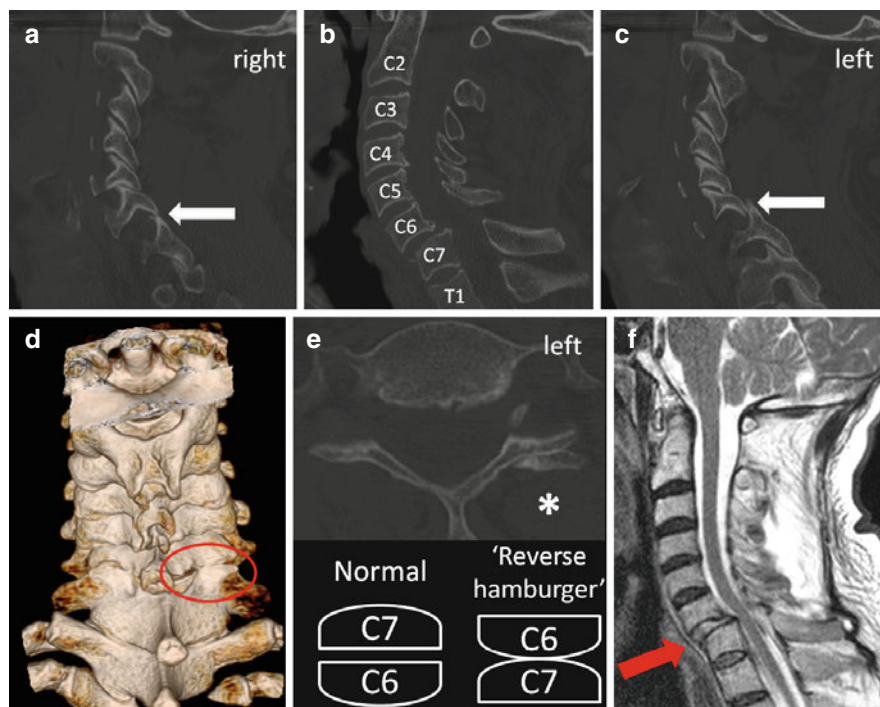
Twenty-nine year old male with known Ghent positive MFS, who was admitted with neck following a trivial fall. No neurological deficit noted on examination. Cervical spine CT reconstructions in the sagittal plane through *right facet complexes* (a), *midline* (b) and *left facet complexes* (c). 3D reconstruction (d) showing the bilateral ‘jumped’ facet joints at C6/C7 (white arrows, red circle on 3D-reconstruction) which is also shown on the axial CT slice through the C6/C7 facet joint (e) revealing the classic ‘reverse hamburger sign’ in the left sided C6/7 facet (* on e), NB not seen on the same CT slice on the right due to angulation of the acquisition). Sagittal T2-weighted MRI shows the step deformity at C6/7 (red arrow), kinking of the spinal cord however no cord compression due to ruptured C6/7 intervertebral disc prior to treatment. He was successfully treated with open (operative) reduction and underwent anterior cervical discectomy and plating followed by the posterior stabilisation using lateral mass screw fixation
